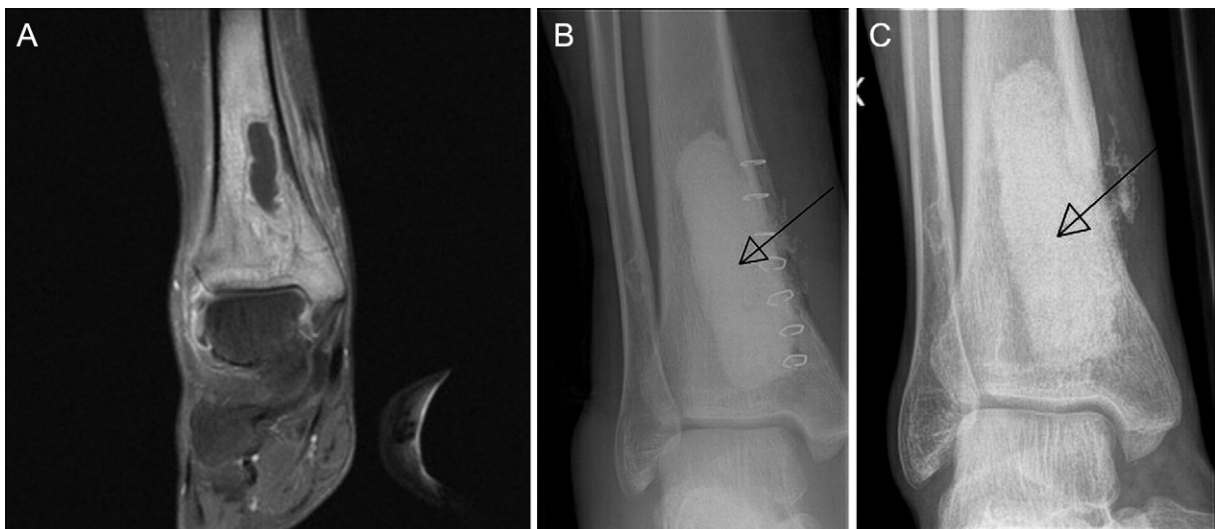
(A–C) Osteomyelitis caused by *S. aureus* in distal tibia treated with BAG-S53P4 as bone graft substitute: (A) preoperative MRI showing osteomyelitis in tibia, (B) postoperative X-ray showing BAG-S53P4 in the treated bone cavity (arrow), and (C) X-ray at five months follow-up showing the treated region (arrow).
